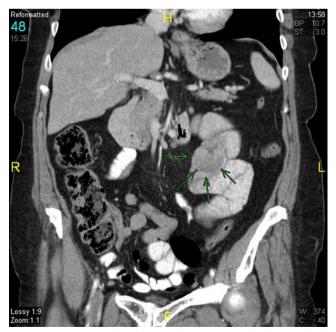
CT scan also showing intussusception in the proximal jejunum with a mass suspicious for neoplasm.
